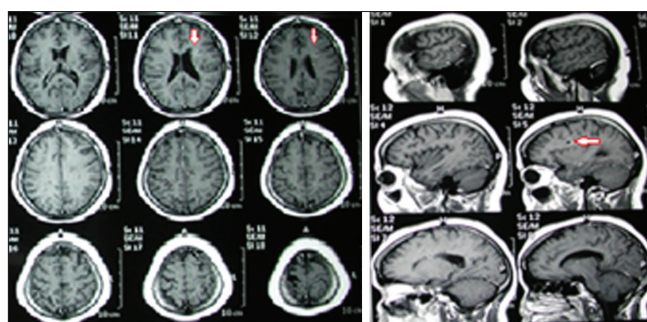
Sagittal brain magnetic resonance imaging view of multiple sclerosis patient before contrast (a) and after contrast (b)
